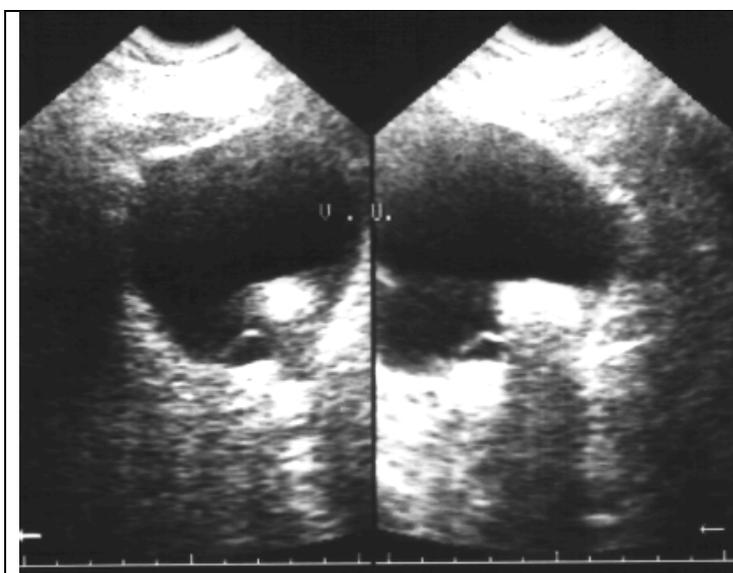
Sonogram of the bladder. A stone in the bladder with hyperechoic frame is defined. Hypoechoic acoustic shadow. Urolithiasis.
